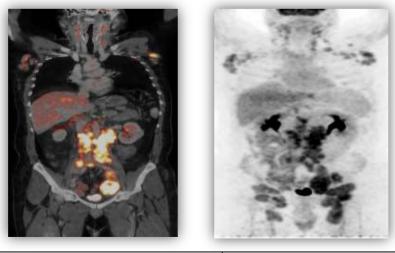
whole body Coronal fused PET/CT image.
